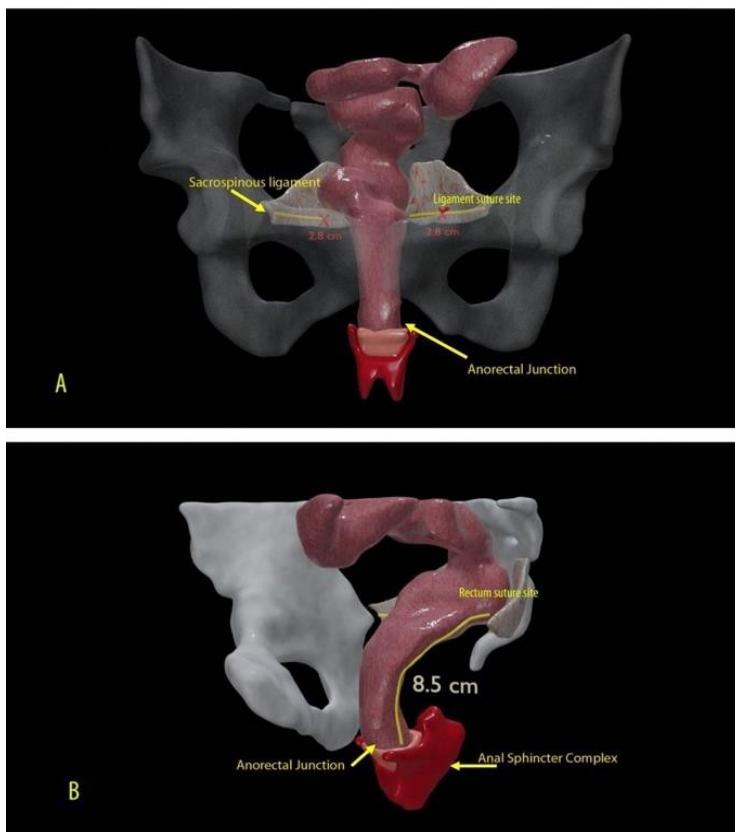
This computational 3D model is created based on MRI images of a normal nulligravid healthy volunteer. The suturing sites on rectum and sacrospinous ligament used for transvaginal sacrospinous rectopexy and related landmarks are demonstrated here in coronal (A) and sagittal (B) views
